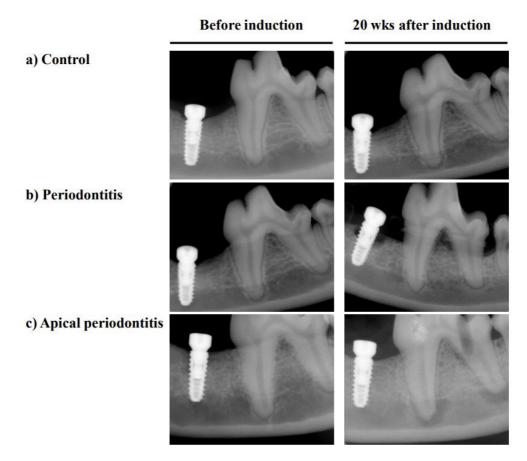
Radiographs obtained before and after induction of experimental periodontitis and apical periodontitis
